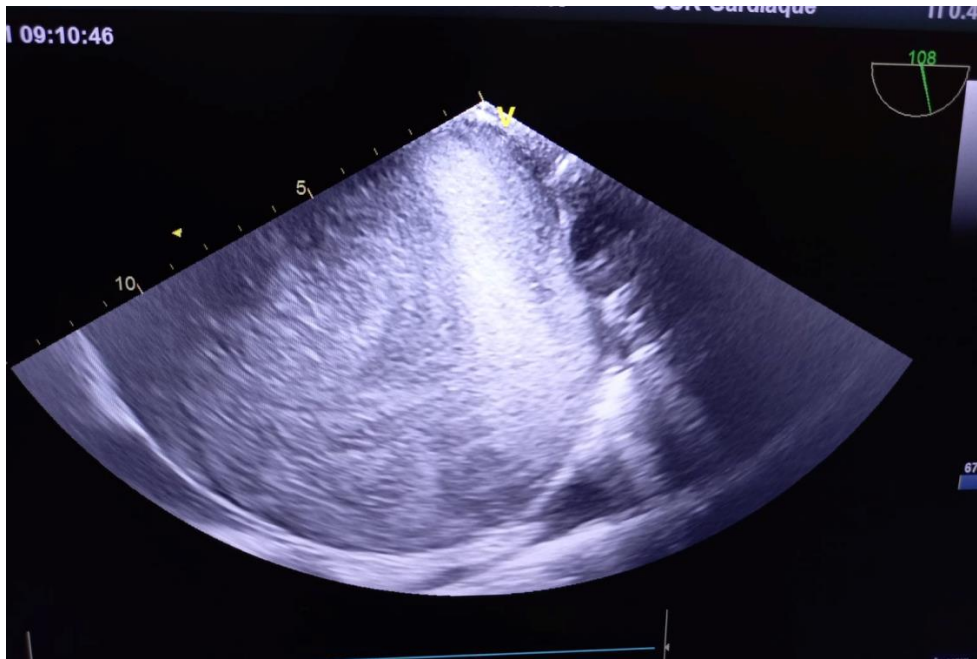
Transesophageal echocardiography showing giant left atrium with “heavy smoke” shadow
